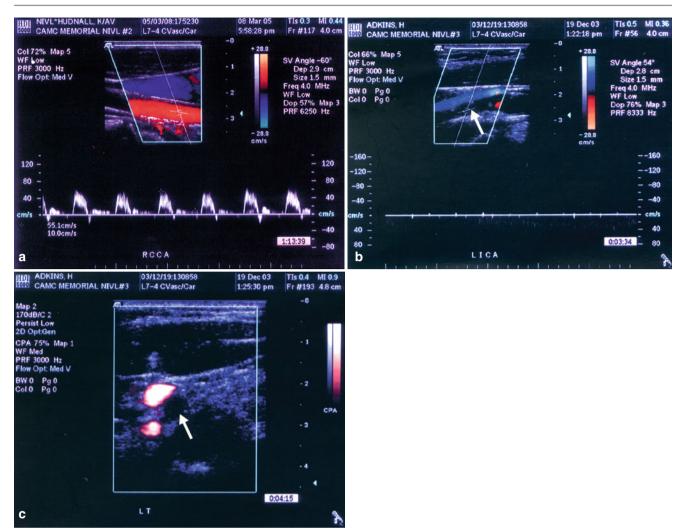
(a) A common carotid artery Doppler spectra produced by occlusion of the ipsilateral internal carotid artery. Peak frequency is not abnormally high, but the characteristic feature is the presence of reverse flow in diastole. (b) Internal carotid artery occlusion in longitudinal view
